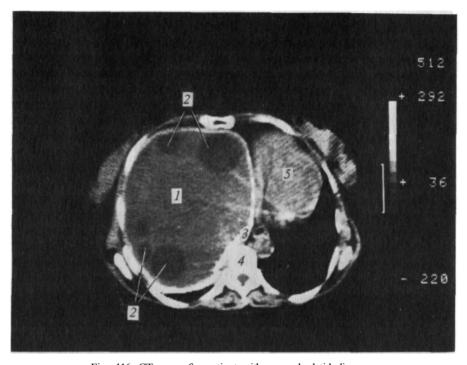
CT scan of a patient with severe hydatid disease.
